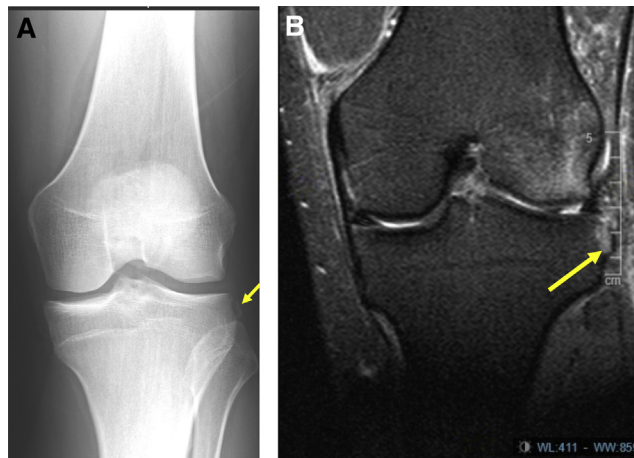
(A) Radiograph of Segond fracture in patient with ACL tear (left knee). (B) Magnetic resonance imaging of Segond fracture in patient with acute ACL tear (left knee). (ACL, anterior cruciate ligament.)
